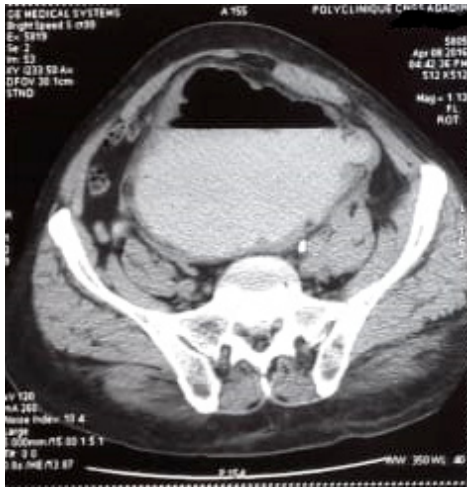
CT scan of the pelvis showing gas in the bladder and the bladder wall.
